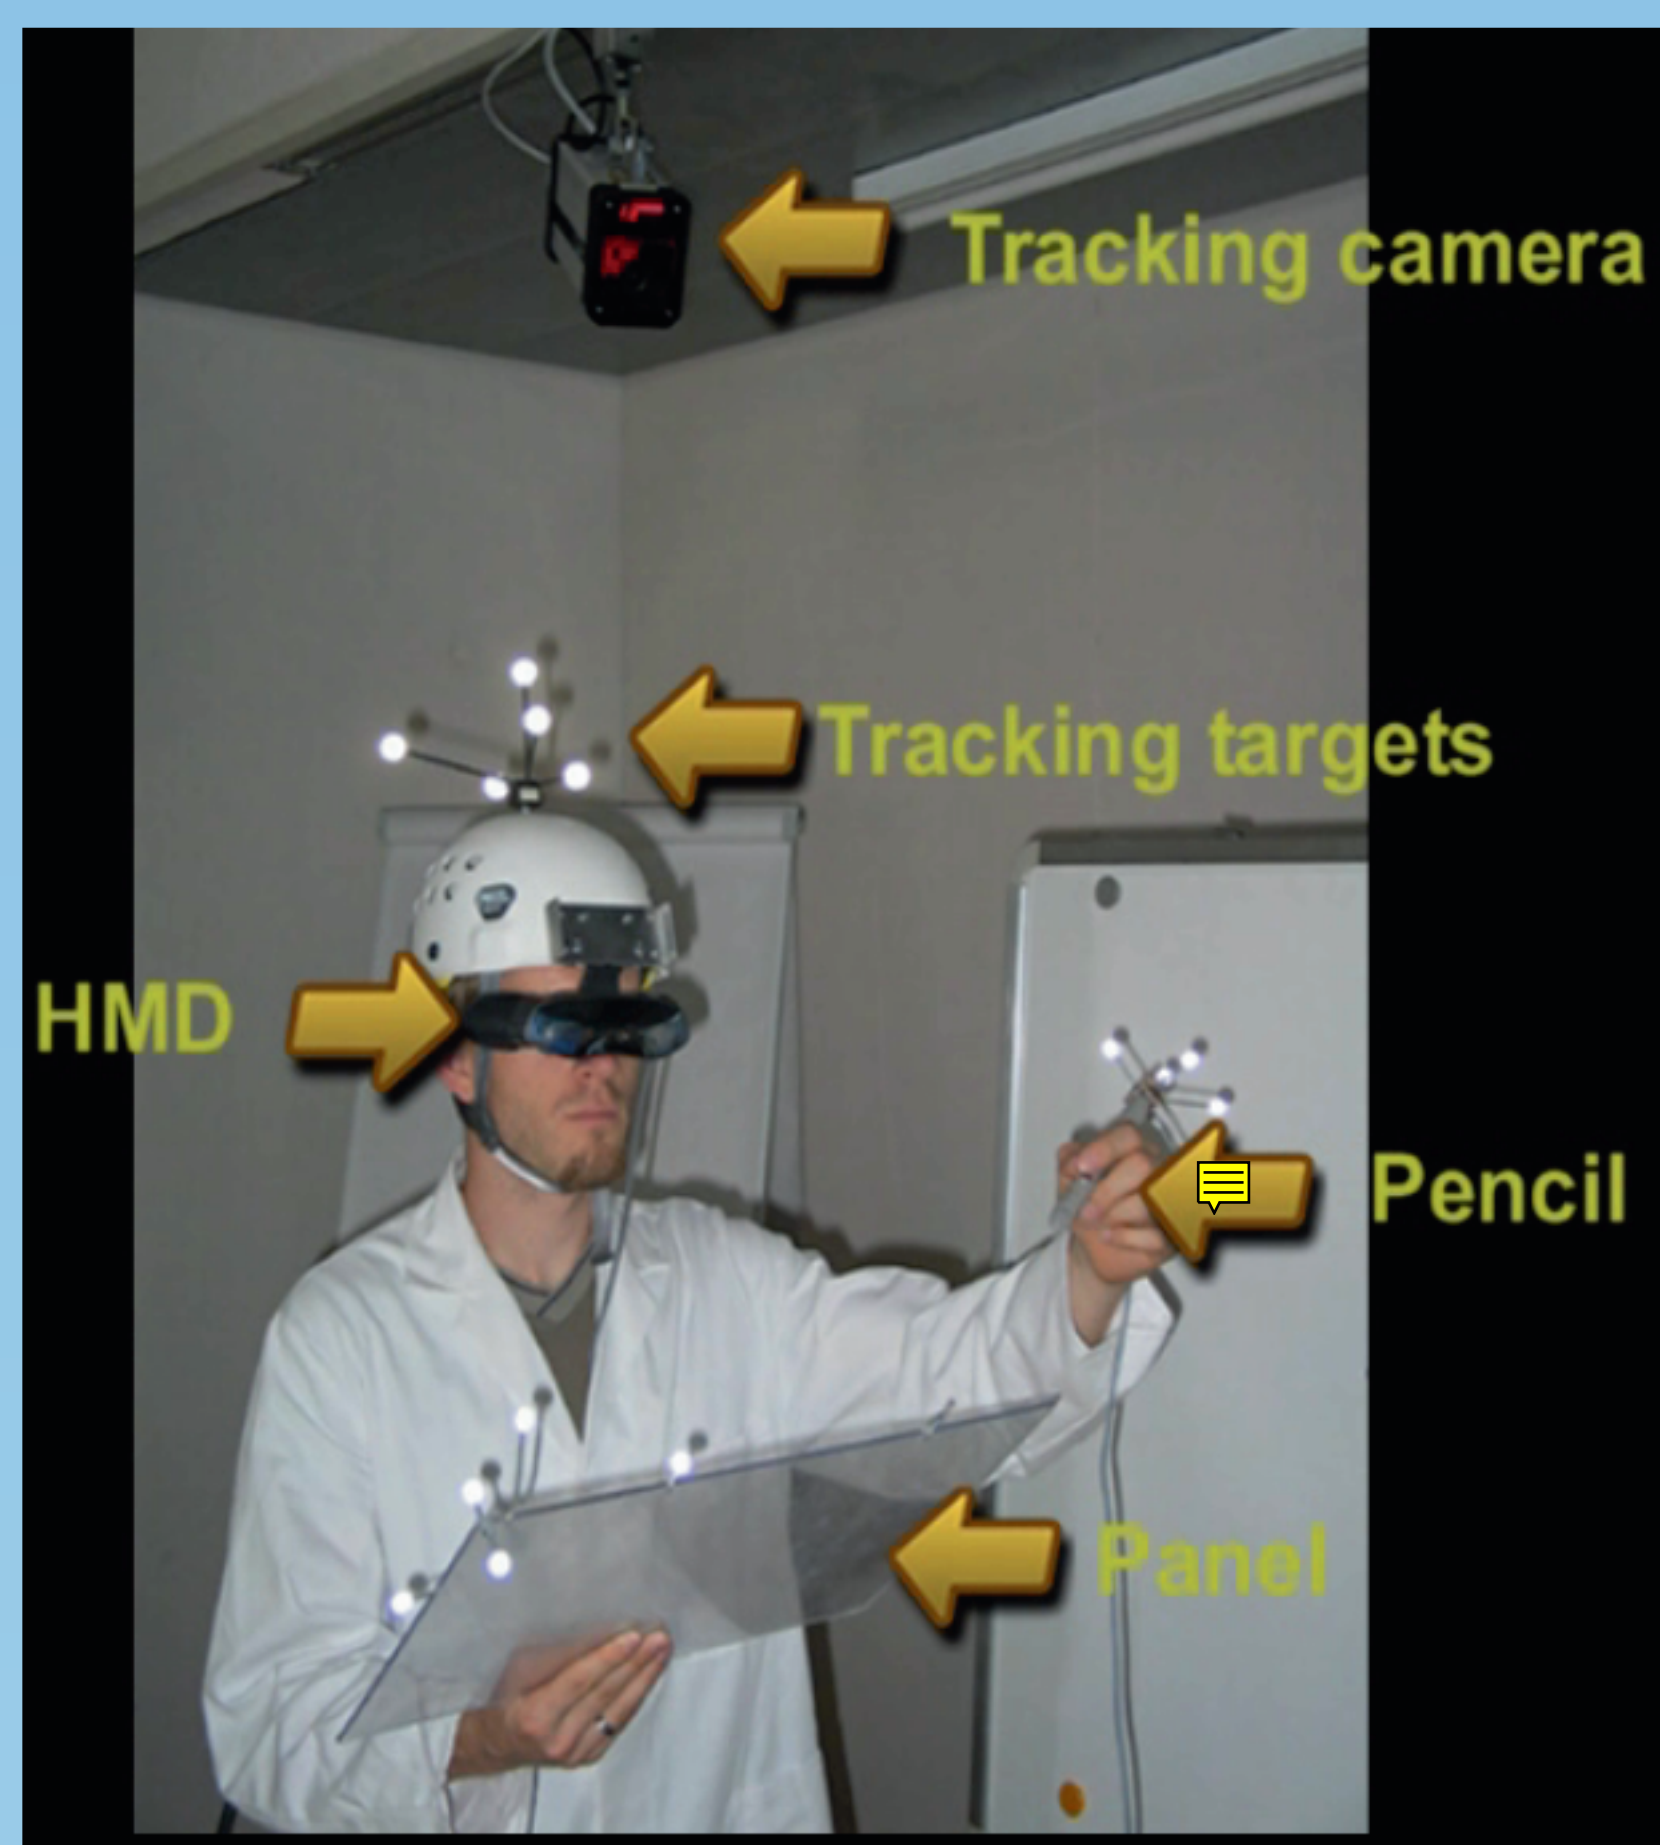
Components of the augmented reality system – operator wears a head mounted display (HMD), on the top of the HMD tracking targets are fixed. The tracking cameras (usually four) send infrared flashes, which are reflected by the tracking targets. This information forms the basis for calculation of the operator's position within the 3D space. The panel represents the interface to the system and covers two tasks, depending on it's position (more details on Fig. 6 and7): one side it displays action buttons and sliders for the operator, if flipped it acts as a cutting device for display of surrounding Spiral – CT data. All actions are carried out using a virtual pencil.
